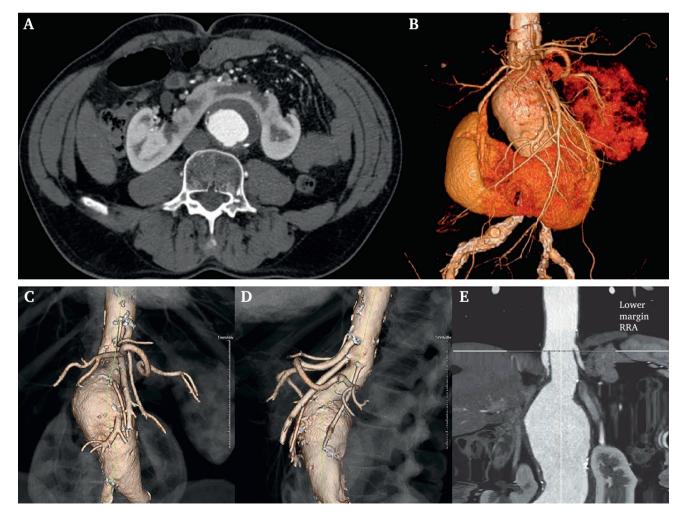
Pre-operative images of the aortic aneurysm and horseshoe kidney. A. Computed tomography angiography scan. B. 3D computed tomography angiography reconstruction. C and D. Renal vessel details. E. Coronal centre line adjusted computed tomography scan.
